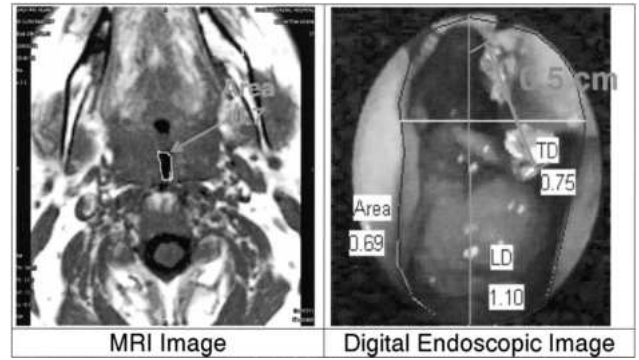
Measurements validation. Comparing the area measurement between the upper airway magnetic resonance image (MRI) and digital endoscopic image at the identical level of upper airway.
